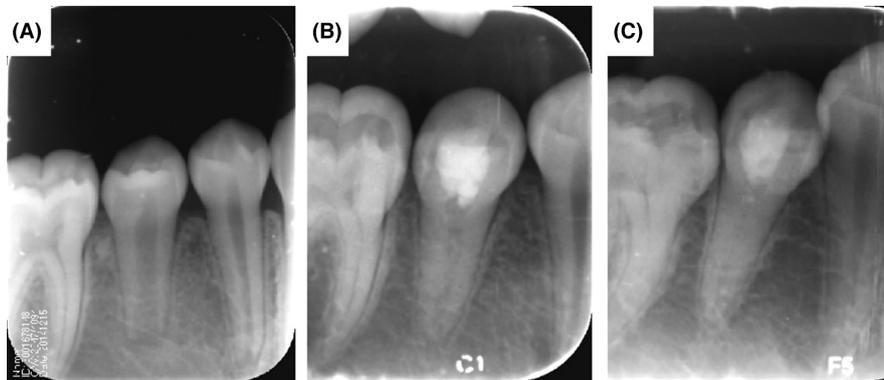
A 14-year-old male patient diagnosed with pulp necrosis. Periapical films of tooth 45 over a 68-month follow-up duration. (A) A postoperative periapical film showing an incompletely developed root with an open apical foramen. (B) A 16-month follow-up periapical film: the root achieved complete development, and diffuse calcification occurred in the root canal. (C) A 68-month follow-up periapical film: the extent of calcification increased, and root canal images were still visible but significantly narrower.
